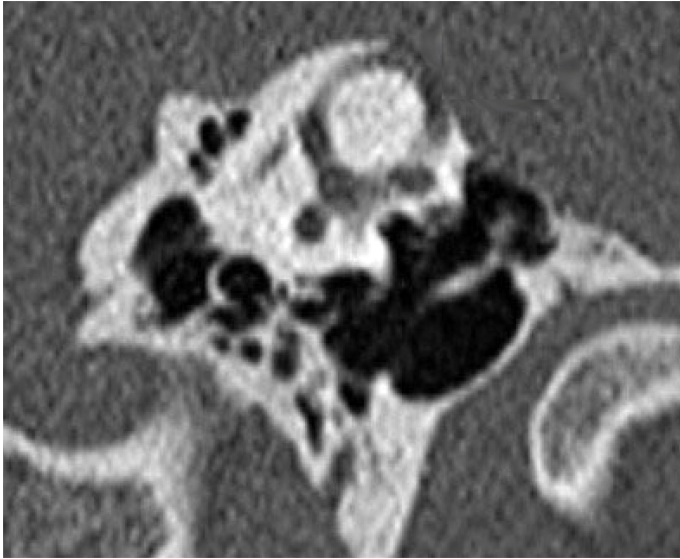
High-resolution computed tomography scan showing a left superior semicircular canal dehiscence.
